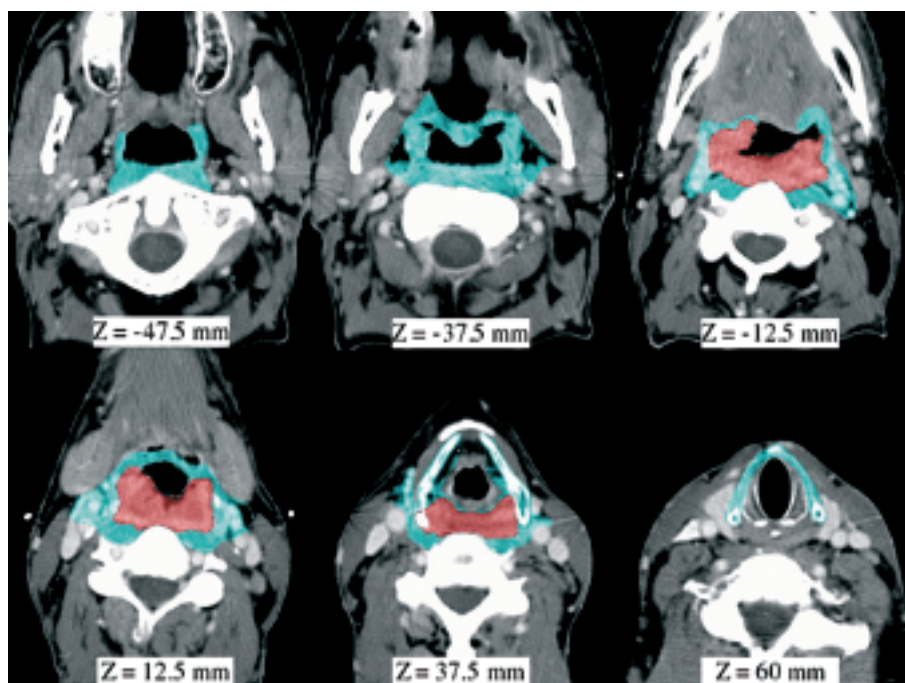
Axial CT slices of a 57y male with a huge T4 tumor of the posterior pharyngeal wall (GTV in red). It extends to both lateral pharyngeal walls. Posteriorly located longus capiti muscles show clear signs of invasion and are largely included in the CTV (in light blue). Because of the lateral extension, the CTV includes cranially the soft palate, in the middle the epiglottis and caudally the thyroid cartilage and both PGS.
